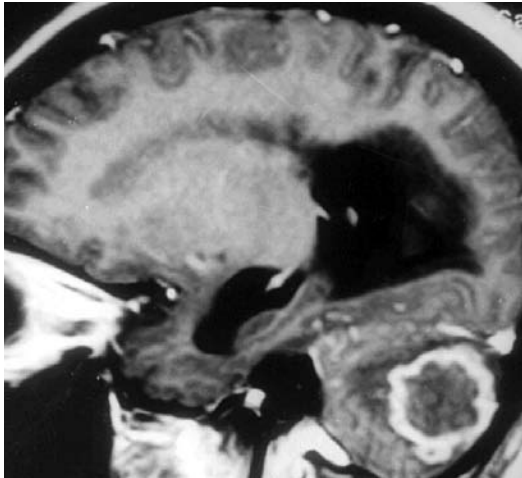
Post contrast MRI in sagittal plane showing a large tuberculoma in cerebellum with edema and hydrocephalus
